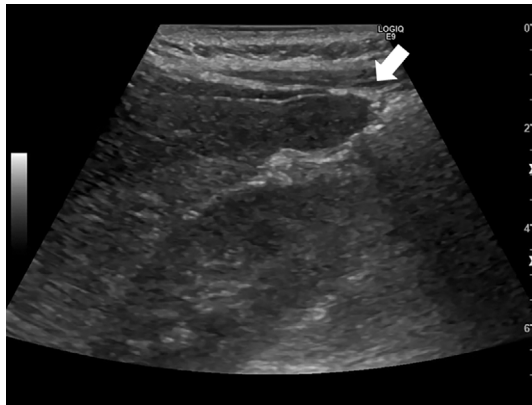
Abdominal ultrasonography performed 1 month before the patient's admission showed a 25-mm uniformly low-echoic mass projecting from the lower end of S6 in the liver (arrow). The border was not clear, and the surface was irregular.
